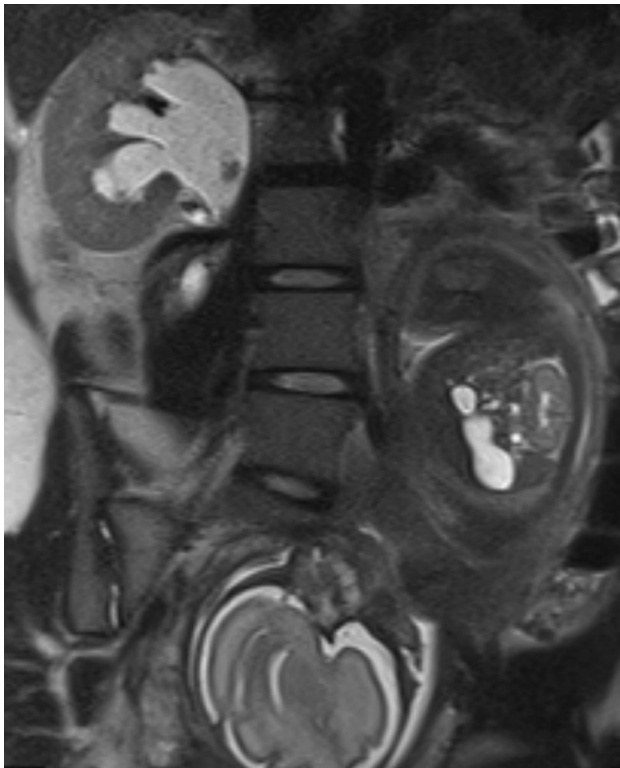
T2 HASTE coronal MR image reveals right ureteropelvic junction calculus and associated hydronephrosis in a pregnant patient
